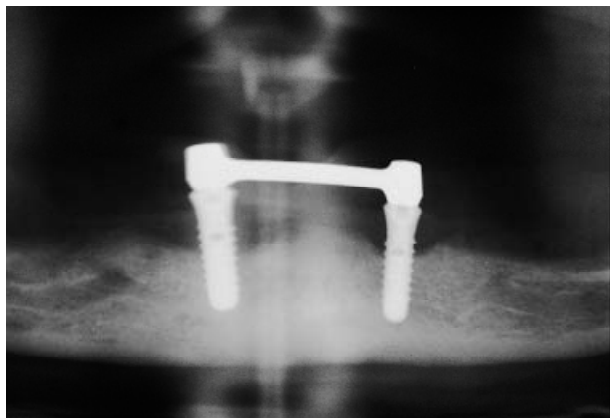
The X-ray at 4 years following surgical treatment with EMD demonstrates a fill of the intrabony defect component (case 1 from Table 1).
